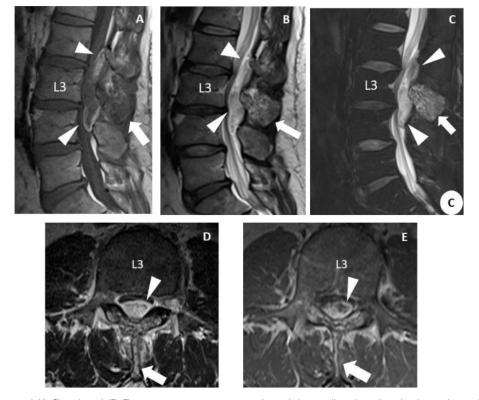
Preoperative sagittal (A-C) and axial (D, E) magnetic resonance images showed the rapidly enlarged epidural mass lesion (white arrowheads) that compressed the spinal cord anteriorly. The intraosseous lesions (white arrows) remained the same size.
